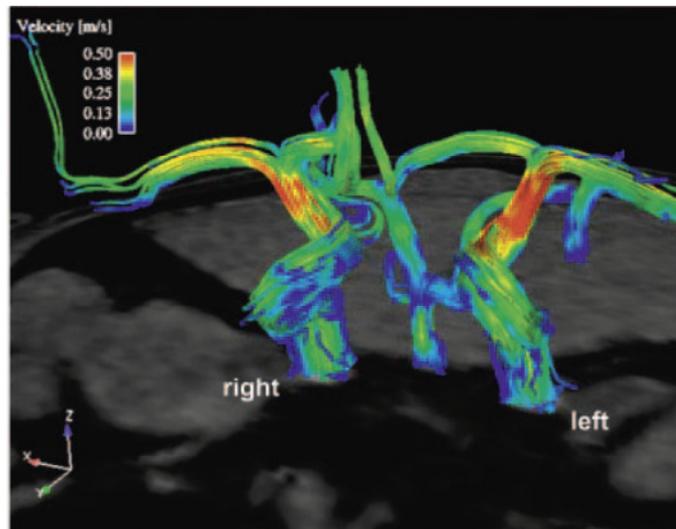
Flow sensitized MRI is capable of capturing and visualizing the intricate behavior of blood flow as it navigates the tortuous neurovasculature. [90] This refinement allows for a researcher or clinician to not only compare intraaneurysmal flow predicted by CFD vs. measured by MRI, but also allows for the confirmation of flow alteration after an AVS has been deployed across the neck of the aneurysm.
